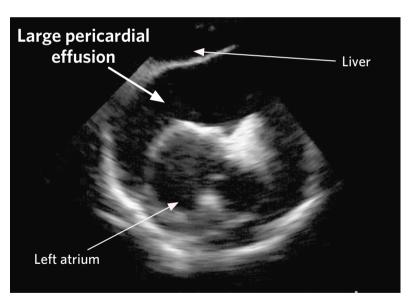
Pericardial Effusion (Parasternal View, top; Subcostal View, bottom)
